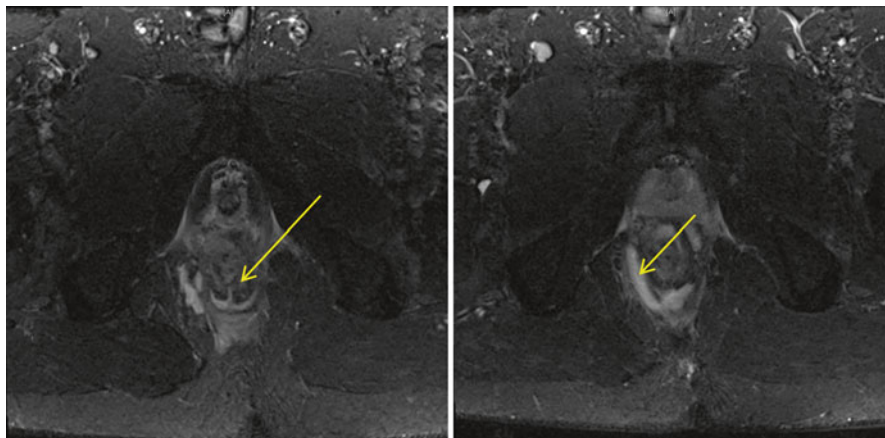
MRI images of the pelvis. Image on the *left* shows an intersphincteric fistula tract at the 6 o'clock position (*arrowed*), and image on the *right* shows a right ischiorectal abscess (*arrowed*), which is communicating with the fistula tract
